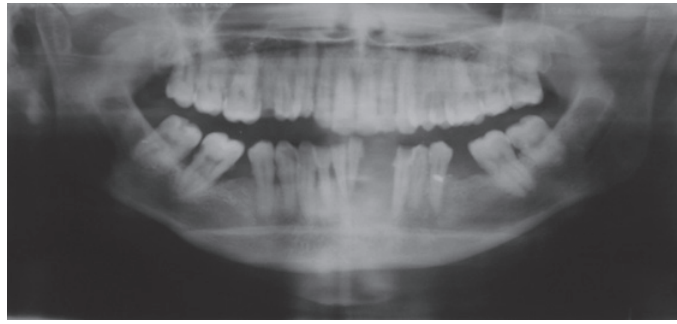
The orthopantomogram revealed loss of the lamina dura in relation to the lower anterior quadrant, with migration of 32 laterally; the 31 exhibited a floating tooth appearance.
